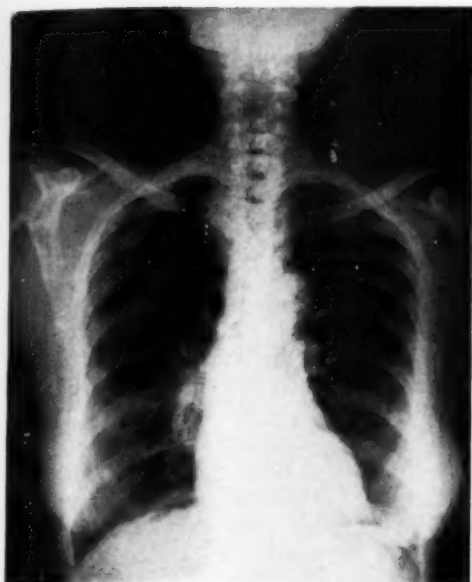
Case III: Postero-anterior roentgenogram showing a rounded density projecting beyond the right heart border, obscuring the right hilus. Contiguity with the descending thoracic aorta both above and below can be faintly distinguished. The greater density of the aorta makes this case less of a diagnostic problem than Cases I and II.
